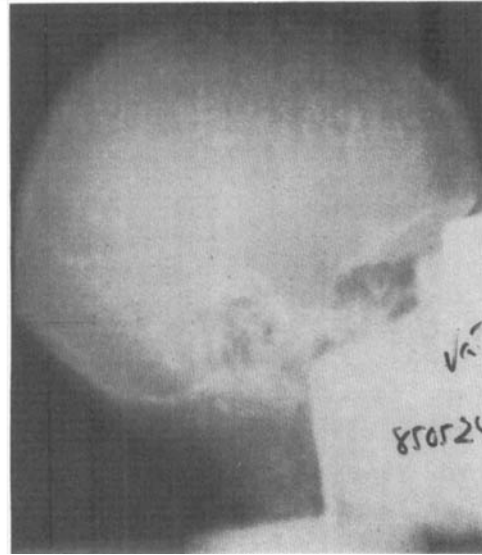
A portal film of the head using 6 MV x-rays.
